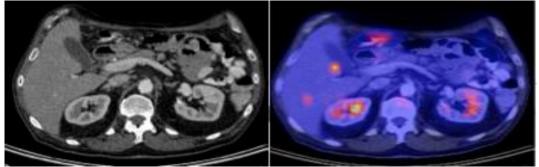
CT and fused PET/CT images of a patient with colonic mass with two hypermetabolic foci within the liver without definite corresponding CT abnormality very worrisome for hepatic metastasis. This case demonstrates the advantage of PET/CT over CT alone in the imaging of distant colonic metastasis.
